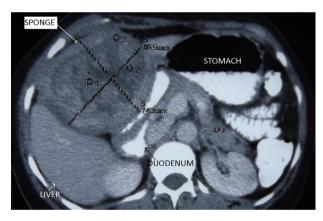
CT image showing a well-defined heterogeneous mass abutting the inferior hepatic surface and indenting the gastric antrum and first part of duodenum.
